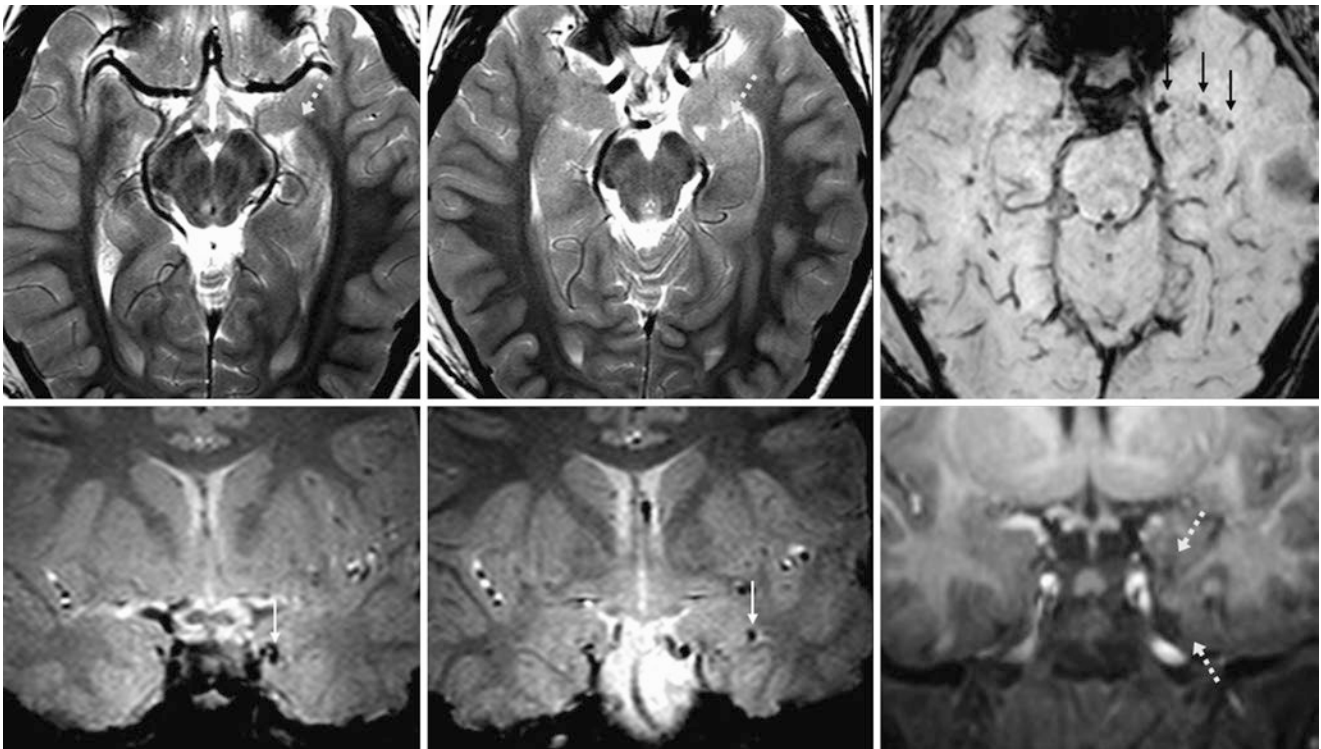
Comparison case of diffuse axonal Injury (DAI). In an 8 year old who had seizures several months post-trauma the 3 T MRI depicted focal left temporal atrophy (*dotted arrows*) on T2WI (*top left and middle*), with microhemorrhages (*thin arrows*) on SWI (*top right*) and coronal T2*WI (*bottom left and middle*). A coronal T1WI (*bottom right*) also showed the focal atrophy
